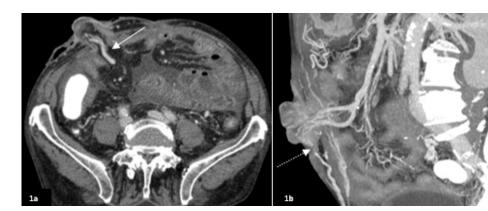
CT angiography in the venous phase. 1a - Axial section and 1b - Sagittal reformatting, MIP. Peristomal varicose veins (white arrow) depending on two branches of the superior mesenteric vein with evidence of portosystemic shunt to abdominal wall veins (dashed arrow).
